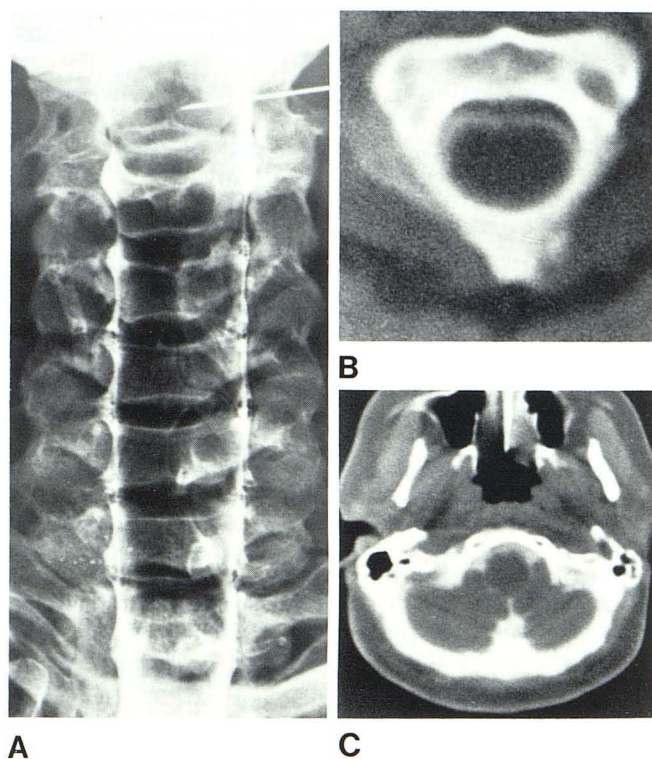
Intramedullary glioma with intracranial extension in 42-year-old woman. A, Cervical myelogram, anteroposterior view. Cervical spinal cord is diffusely enlarged from level of T2, but upper limit of cord widening is not delineated. B, CT myelogram at C2 level. Spinal cord is diffusely enlarged. C, At level of inferior medulla. Medulla is concentrically enlarged. Images obtained at higher levels demonstrated pons to be normal in size.
